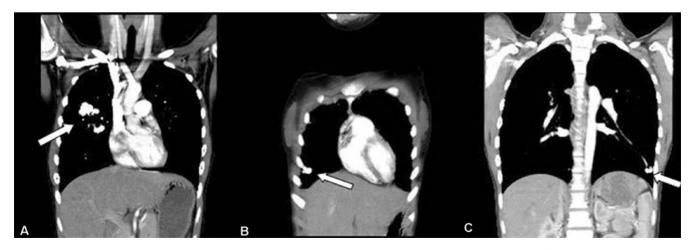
The chest computed tomography demonstrates pulmonary arteriovenous malformations (arrows) in the middle and lower lobe in the right lung (A, B) and lower lobe of the left lung (C).
